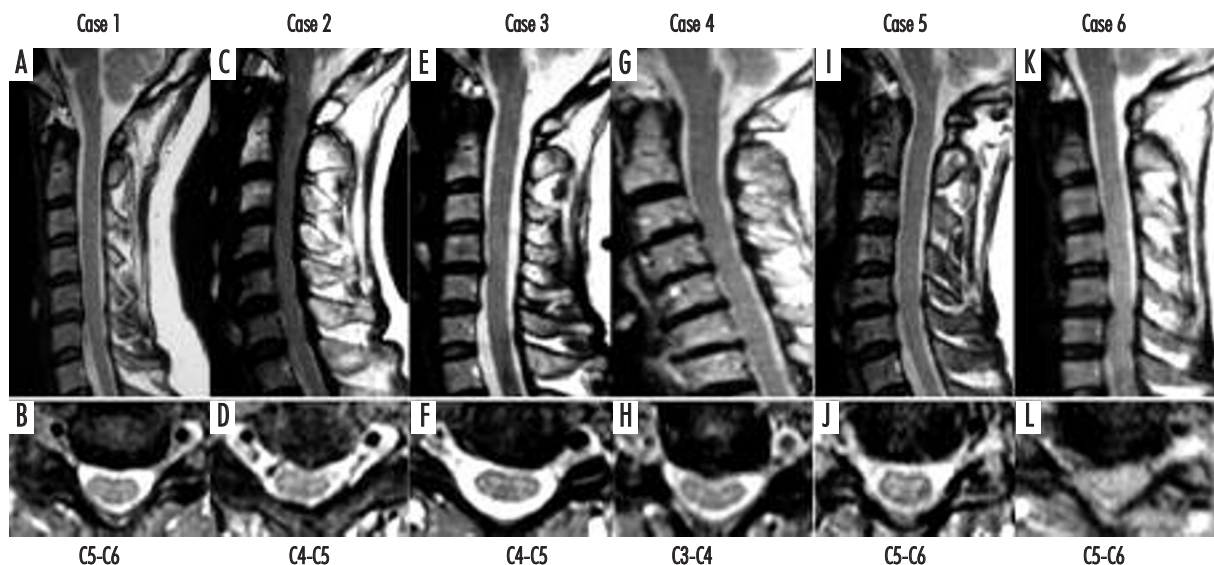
Spinal MRI in sagittal and axial planes showing cervical cord in patients with spinal cheiro-oral syndrome. A bean-shaped cord compression (Case 2, 4, 6), intrinsic cord damage (Case 1, 2, 4, 5, 6), cord displacement with anterior flattening in one patient (Case 3), and mild cord displacement without anterior flattening in one patient (Case 1) were seen
